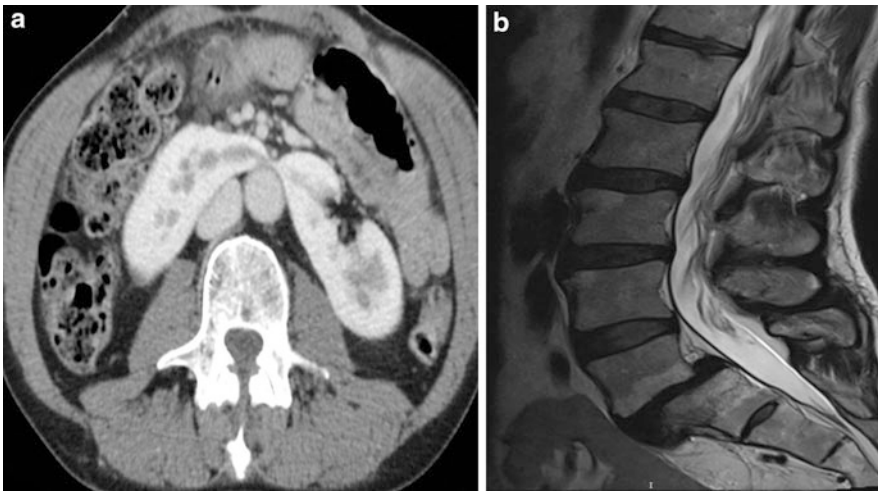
Renal anomalies – (a) Horseshoe kidney overlying the great vessels (b) intrapelvic kidney lying in proximity to L5-S1 on a pre-op MRI of a patient to undergo correction of L5-S1 spondylolisthesis
